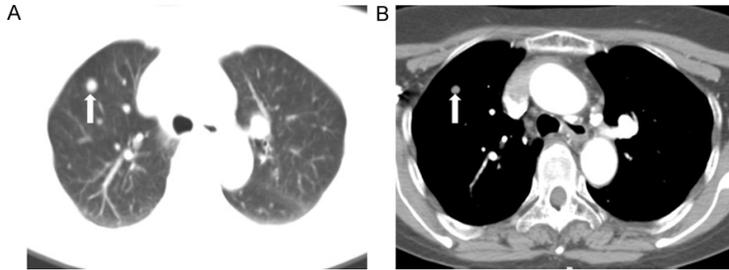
A 66-year-old patient, preoperative CT showed a right upper pulmonary nodule (size 0.50 cm).
